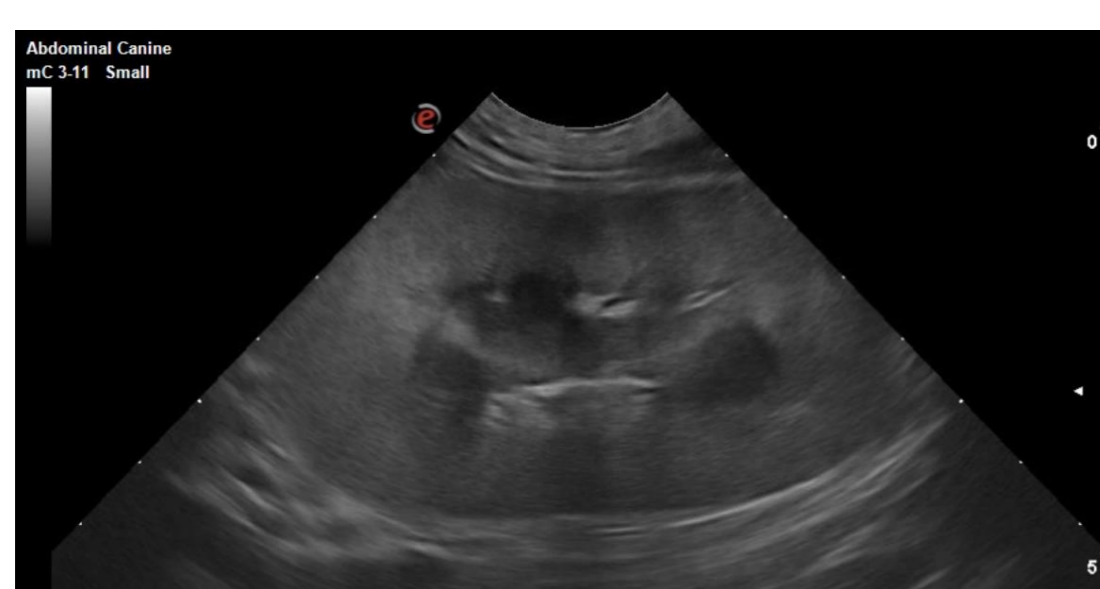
Ultrasound aspect of the left kidney (original)
